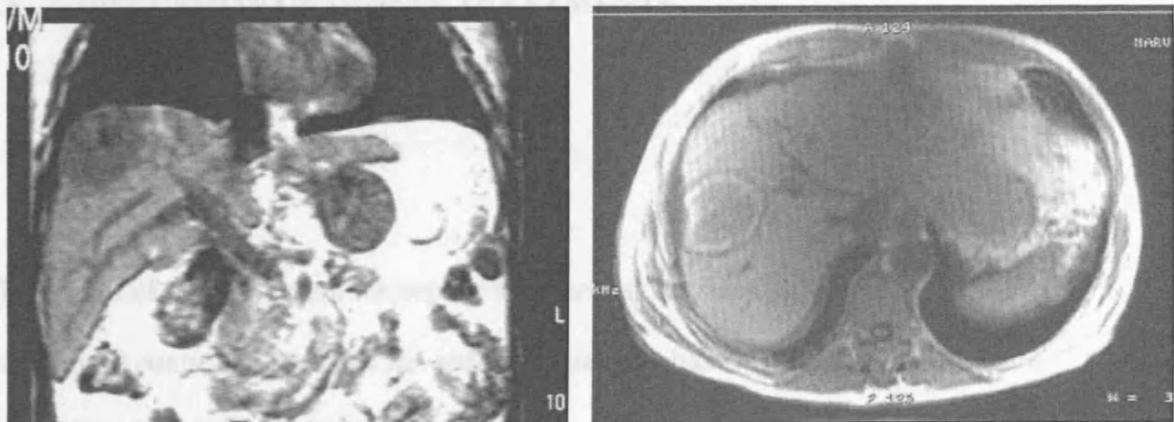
Patient with a single, large hepatocellular cancer which was ablated using the 2.45 GHz equipment. The preoperative MRI (left) shows the lesion in segment 8/4. The post-operative MRI scan (right) shows the lesion 12 months post ablation. No evidence of local or organ recurrence can be seen.
